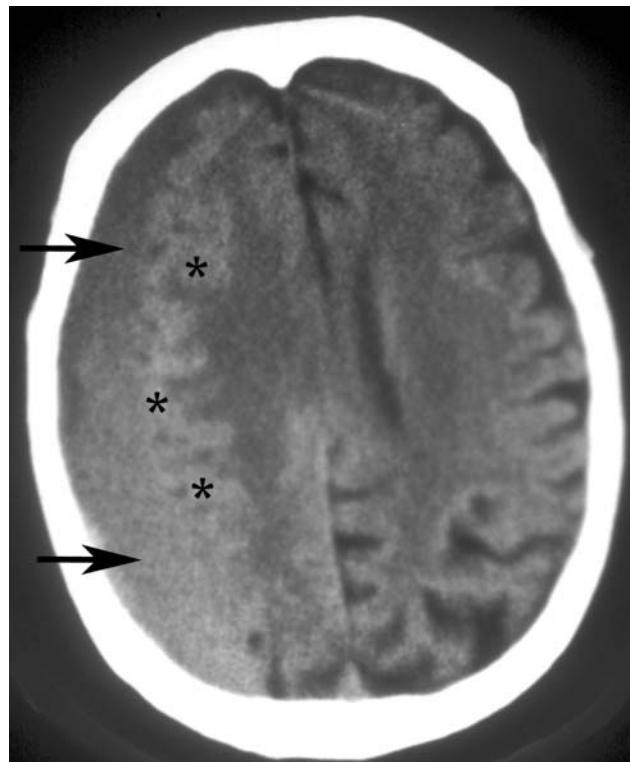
A CT scan of a chronic subdural hematoma (arrow) that covers the entire right cerebral hemisphere. Note how a subdural hematoma forms a crescentic shape on a CT scan. The blood in a chronic subdural hematoma is less bright than the signal made by fresh blood in an acute subdural hematoma (see Fig. 22). The brighter convoluted surface of the cerebral cortex can be seen beneath the hematoma (asterisks). The left cerebrum shows evidence of atrophy, as a dark subarachnoid space is evident beneath the calvaria (bright white) contralateral to the subdural hematoma.
